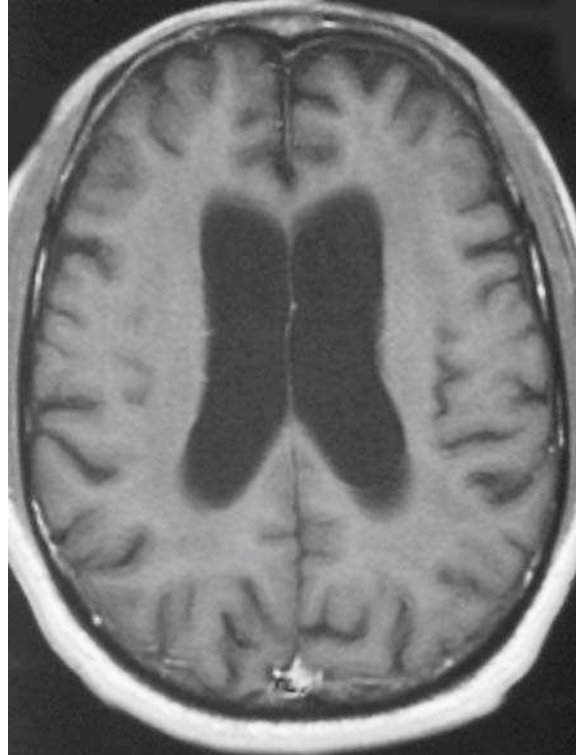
T1-weighted image of an HIV patient with enlarged lateral ventricles (general a non-specific sign of atrophy). Images courtesy of Peter Hildenbrand, MD
